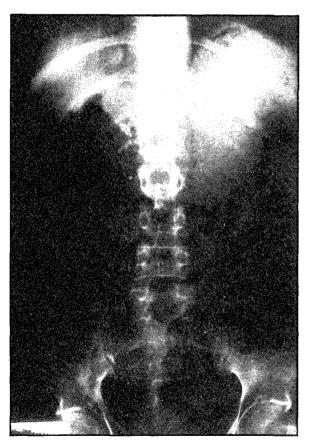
Plane abdominal x-ray of Case 1 showing irregular, spotty pancreatic calcification.
